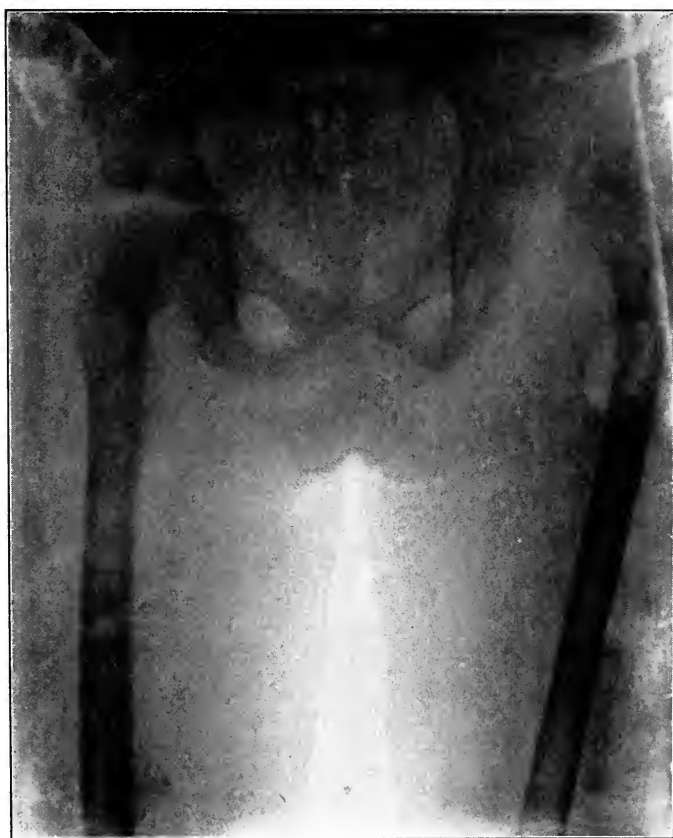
UNILATERAL CONGENITAL DISLOCATION OF THE FEMUR. (X-ray by the author.)
